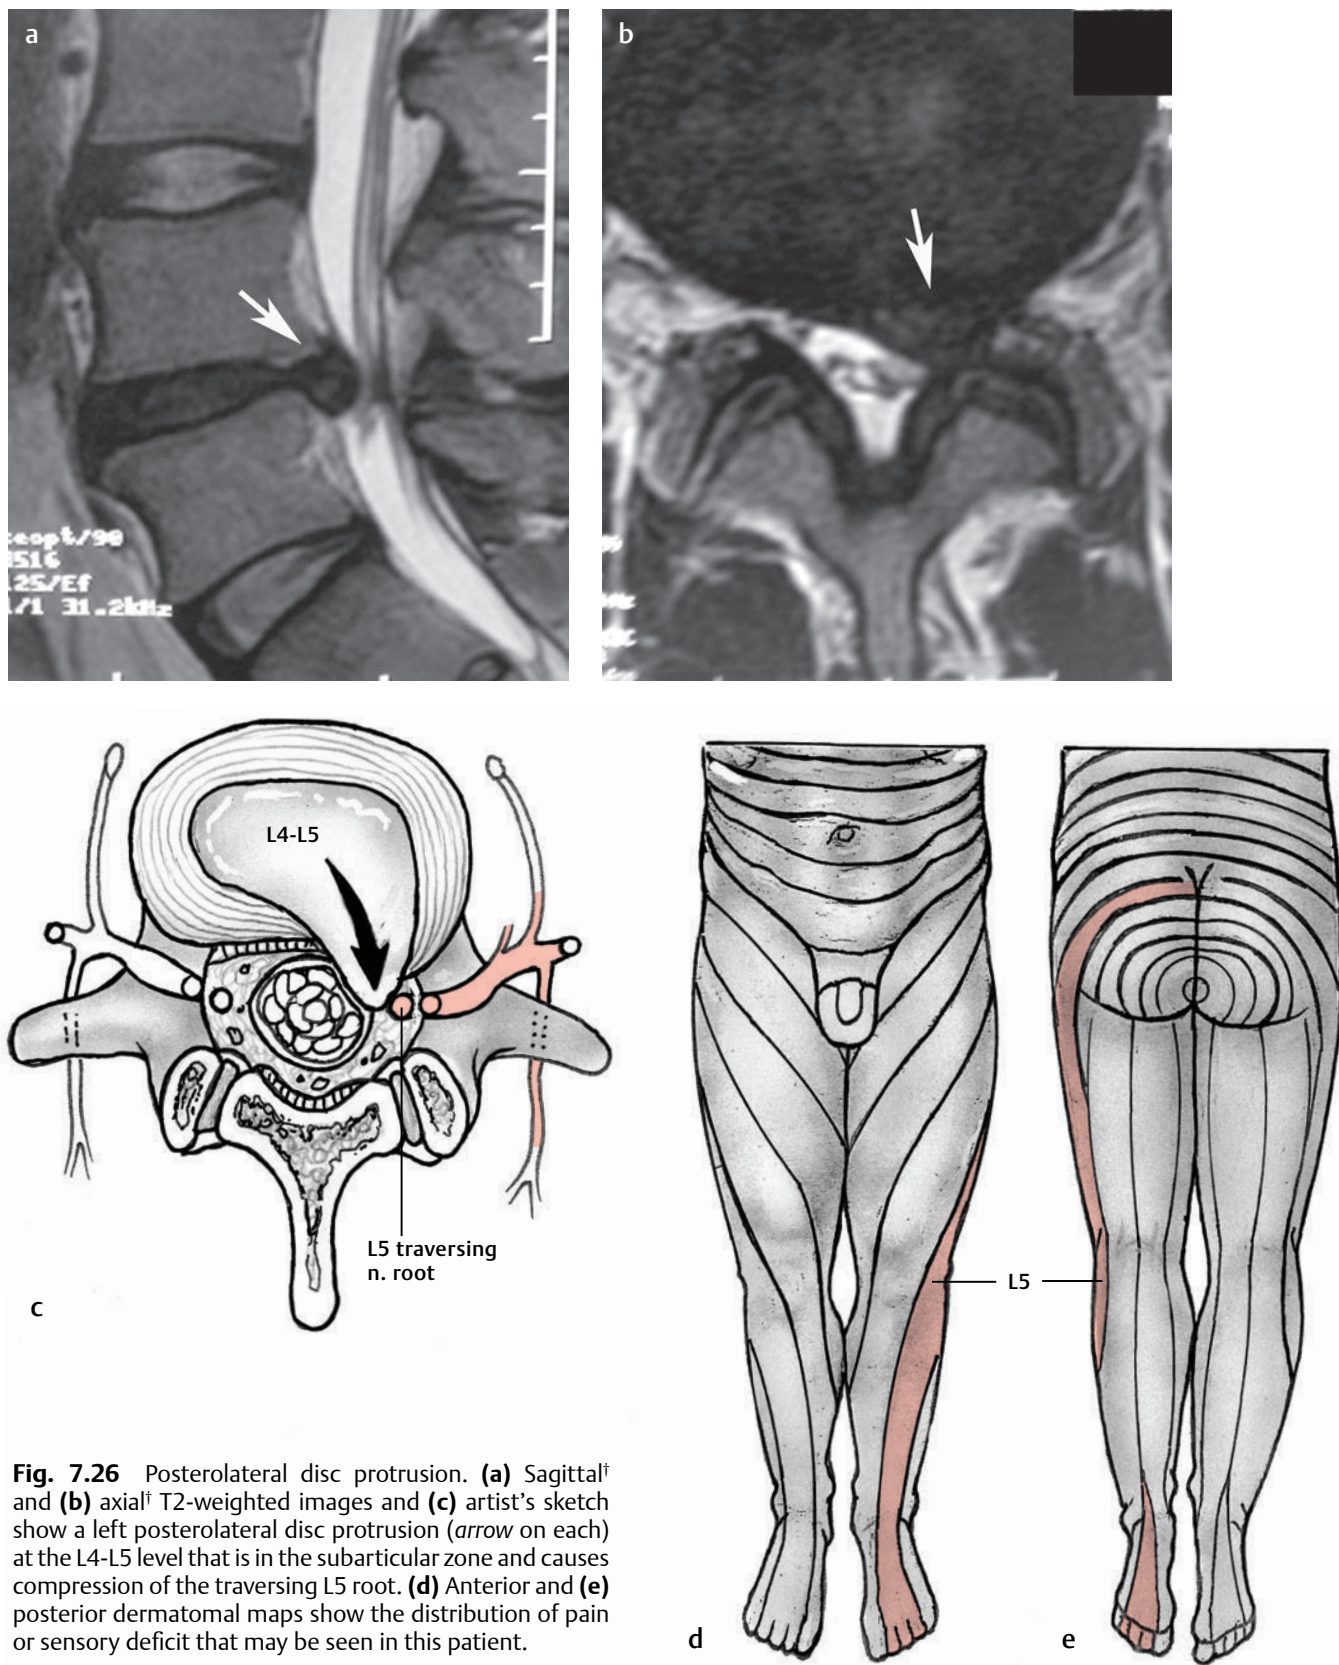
Posterolateral disc protrusion. (a) Sagittal and (b) axial T2-weighted images and (c) artist's sketch show a left posterolateral disc protrusion (arrow on each) at the L4-L5 level that is in the subarticular zone and causes compression of the traversing L5 root. (d) Anterior and (e) posterior dermatomal maps show the distribution of pain or sensory deficit that may be seen in this patient.
